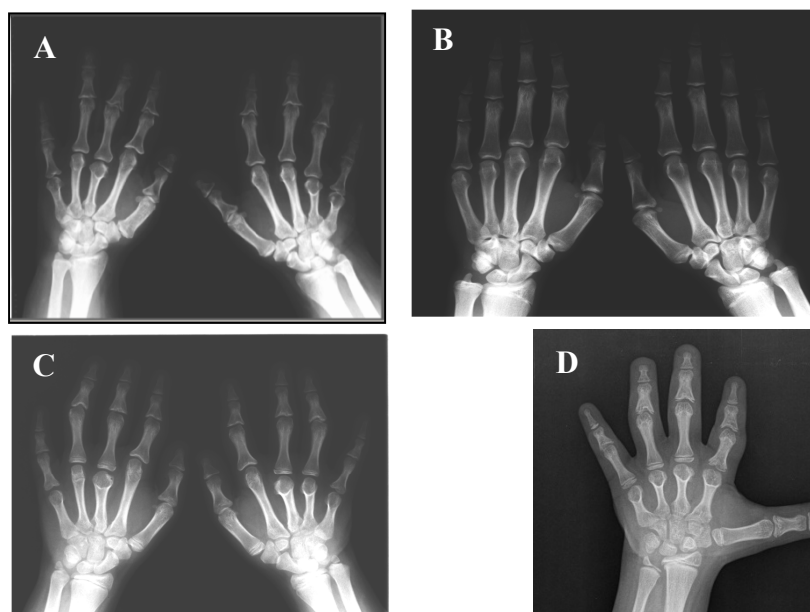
Hand X-rays of (A) patient 1 showing cone-shaped epiphyses and outcarving cones of middle and terminal phalanges of both hands, shortening of metacarpals and proximal and middle phalanges; (B) the unaffected son and (C) the affected daughter. (D) Left hand X-ray of patient 2 also revealing cone-shaped epiphyses and outcarving cones of middle and terminal phalanges, shortening of metacarpals and proximal and middle phalanges.
